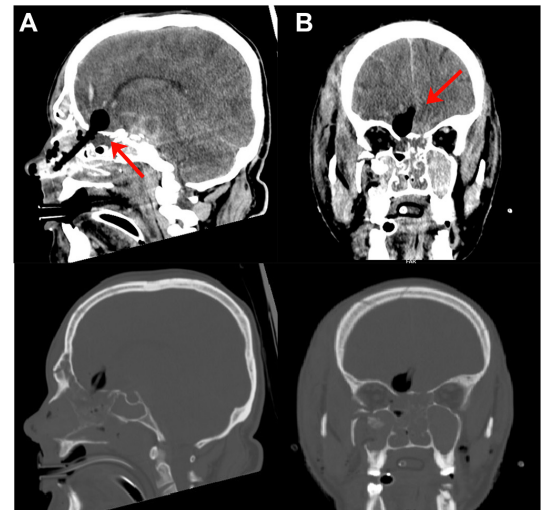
CT of the brain with fractures of the cribriform plate, ethmoid sinus and misguided Foley catheter with inflated bulb lying just above the cribriform plate with their corresponding bone windows. (A) sagittal view and (B) coronal view.
